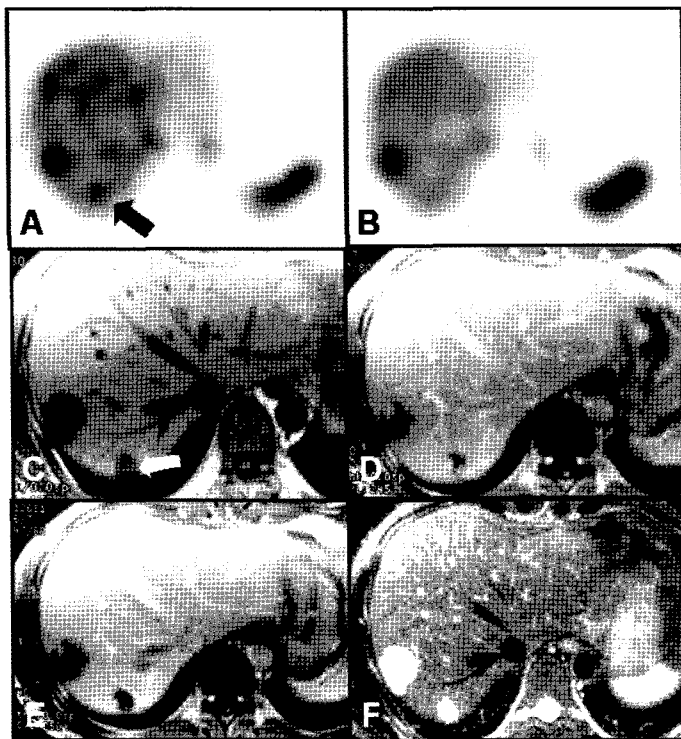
The large hemangioma involving anterior portion of segment 7 is well depicted on both OSEM (A) and FBP (B), however small lesion on posterior portion (arrow) is detected by OSEM only (A). Dynamic enhanced MRI (C-F) clearly demonstrated two hemangiomas having typical findings, the peripheral enhancement and T2 high signal intensity.
